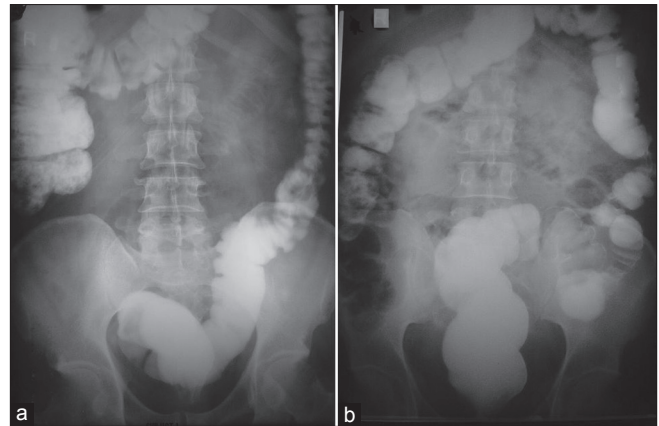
Radiographs of subject a and b
